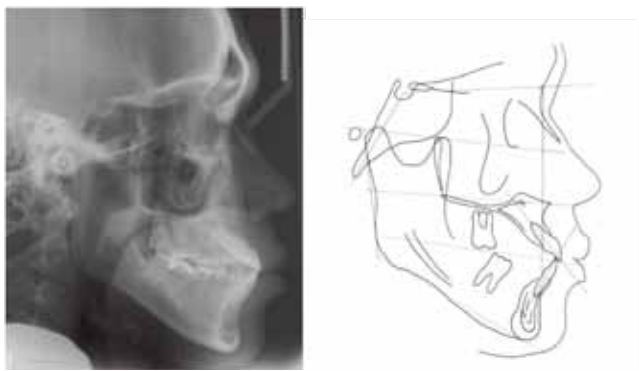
Case 1, pretreatment cephalometric radiograph and tracing
